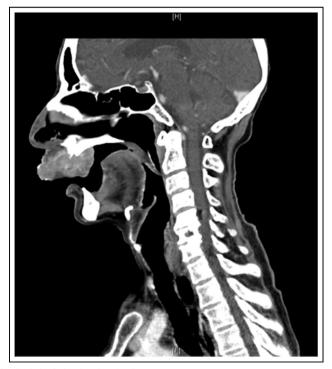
CT head and neck (sagittal view) showing the alveolar mass.
